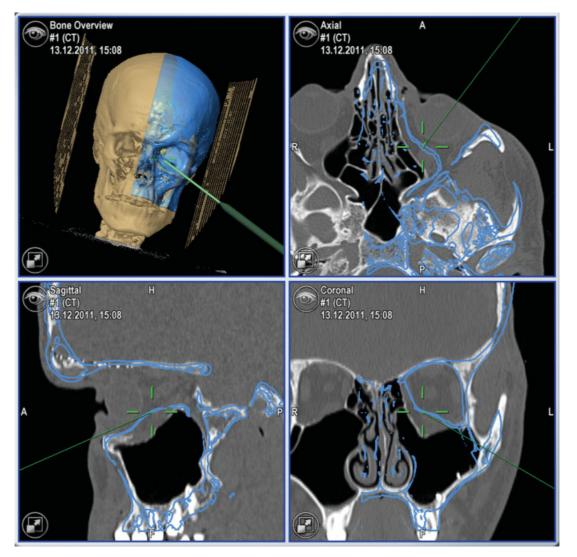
Posttraumatic secondary reconstruction of the left orbit: intraoperative navigation. Intraoperative multiplanar display shows pointerbased surface matching after titanium mesh insertion for left orbital reconstruction. Correct implant position is checked by comparing the pointer tip (green line) with the virtual reconstruction template (blue segmentation). Abbreviation: CT, computed tomography.
